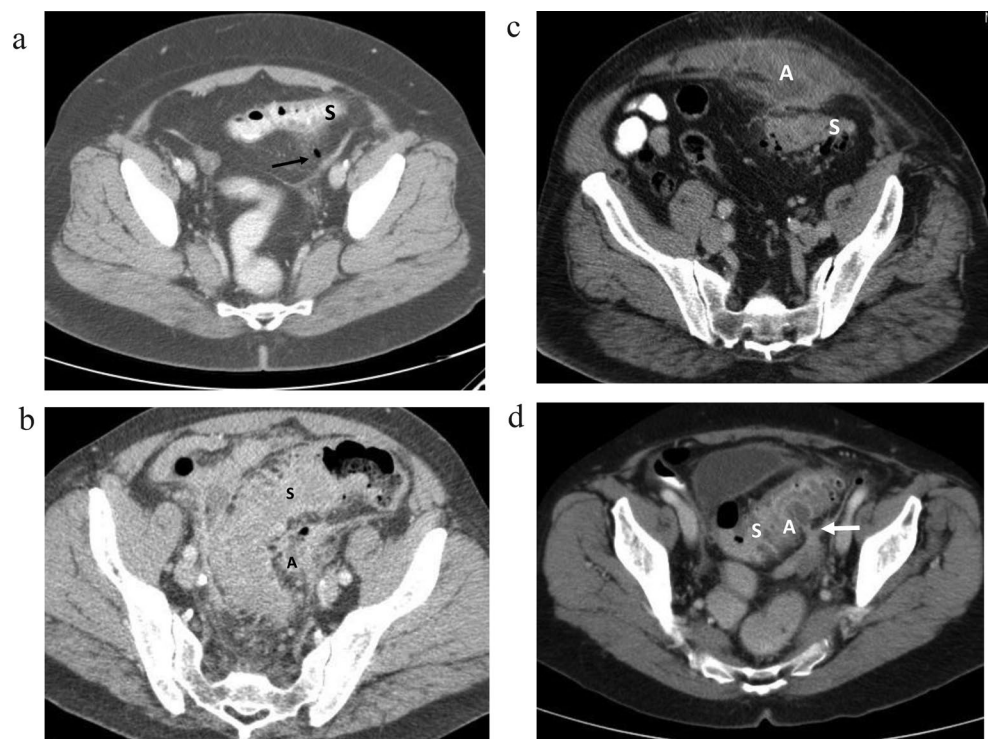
a-d. CT scans of patients with diverticular perforations directed towards structures other than the small bowel. a— perforation towards the retroperitoneum, b— perforation with an abscess towards the pelvic wall, c— perforation with a large abscess directed towards the abdominal wall and bladder (not seen in picture), d - perforation with an abscess towards the lateral pelvic wall. S— sigmoid, A— abscess, arrow— site of perforation
